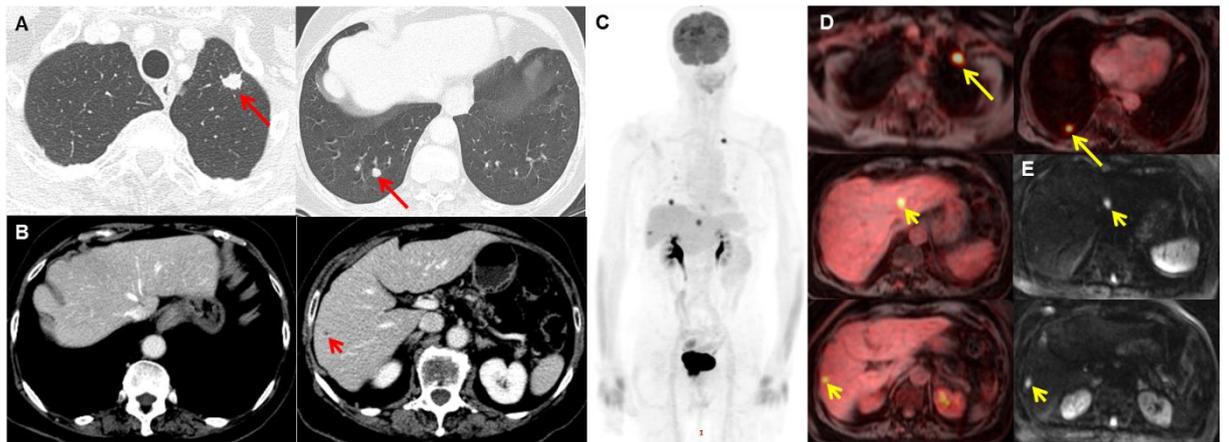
PET/MRI is superior to CS for staging primary rectal cancer with EMVI. The patient was an 85-year-old woman. Thoracic CT (A; long red arrows) and PET/MRI (D; long yellow arrows) revealed lung metastases. Abdominal CT (B) detected an indeterminate liver nodule (short red arrow). The PET/MRI findings (E) indicated that this nodule was suspicious (restricted diffusion and focal FDG uptake) and additionally revealed liver metastases (yellow short arrows). These lesions were confirmed by imaging follow-up.
